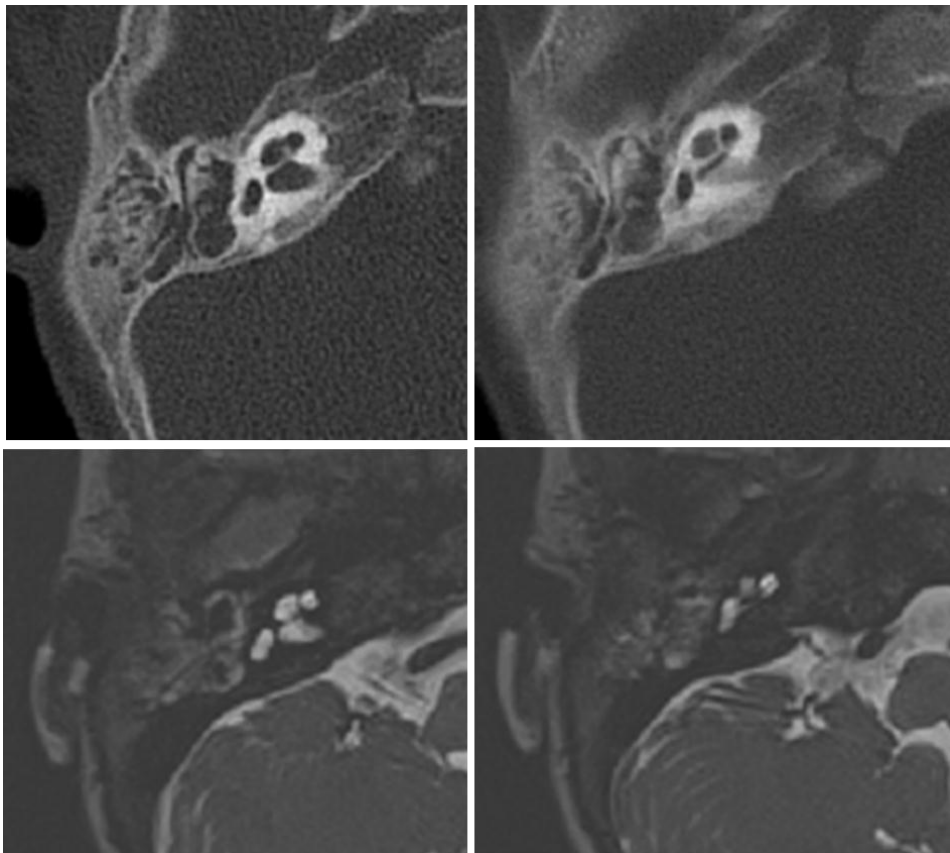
Axial CT scan showing an incomplete partition type III (black arrows) and cystic aspect of the vestibular system (red arrow).
